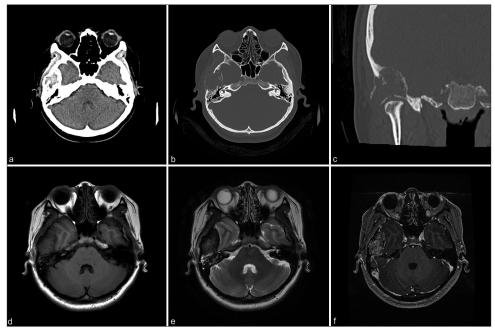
(a) Computed tomography (CT) demonstrating a temporal bone tumor. (b, c) CT bone window shows an expansive and destructive process in the temporal bone that extends to the external auditory canal, middle ear, temporomandibular joint roof, and mastoid air cells. (d, e) Initial head magnetic resonance imaging (MRI) revealed a well-delineated solid extra-axial isointense signal in the right temporal bone in T1 and T2 sequences. (f) A gadolinium contrast MRI T1 sequence shows strong enhancement.
